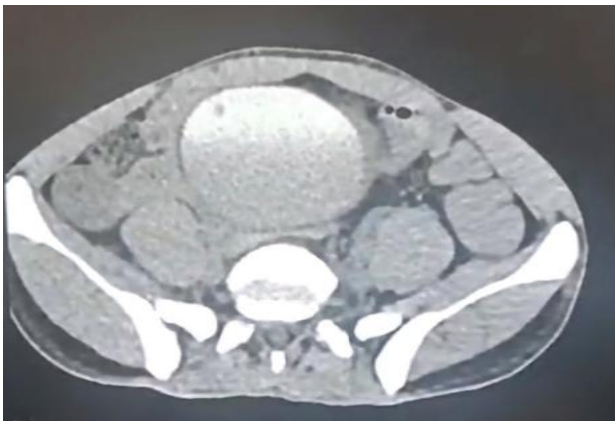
CT image of abdomen at the level of intraperitoneal part of bladder showing no contrast leak in the bladder.
